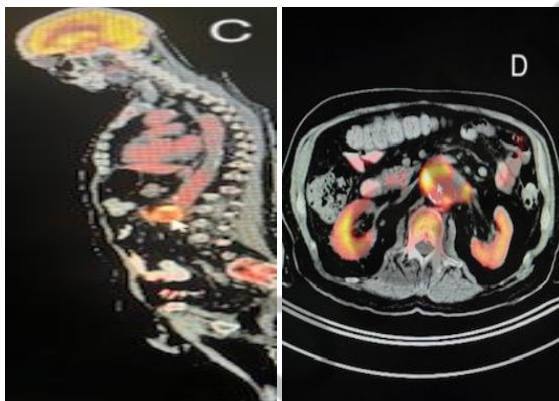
(Panel C / Panel D) - PET-CT showed aneurysmal expansion at the level of the abdominal aorta and renal artery with widespread FDG uptake (SUV: 9.1)
